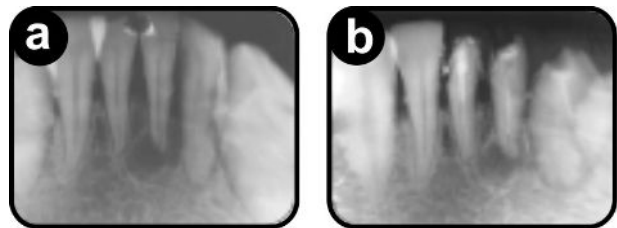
X-ray findings in Case 2. a: X-ray image of an cystic apical granuloma round a mandibular tooth, before treatment. b: X-ray image of the same mandible tooth after eight weeks of treatment with calcium hydroxide without LLLT. There is still inflammation in the apical area with no mineralization of the tooth apparent.
